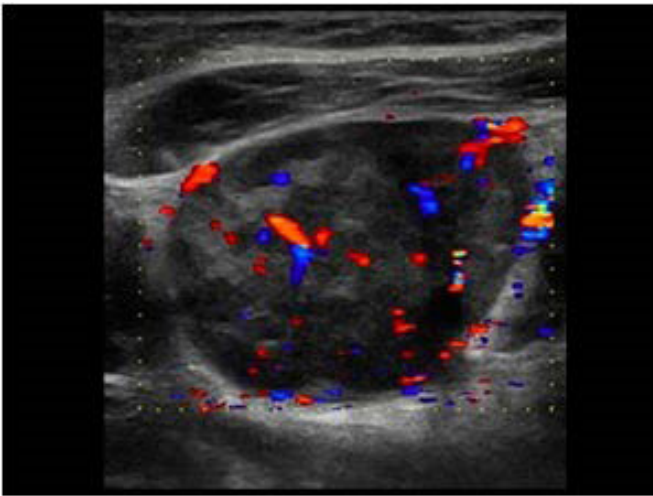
Colour doppler parenchymal pattern of flow
